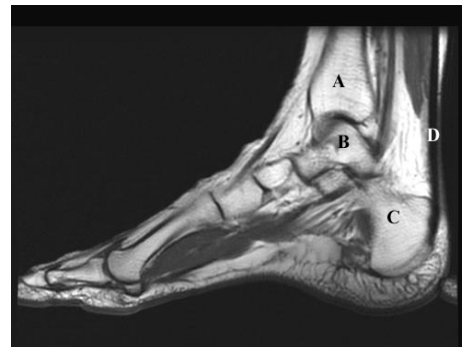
T1-weighted sagittal foot. A-tibia, B-talus, C-calcaneus, D-Achilles tendon*
